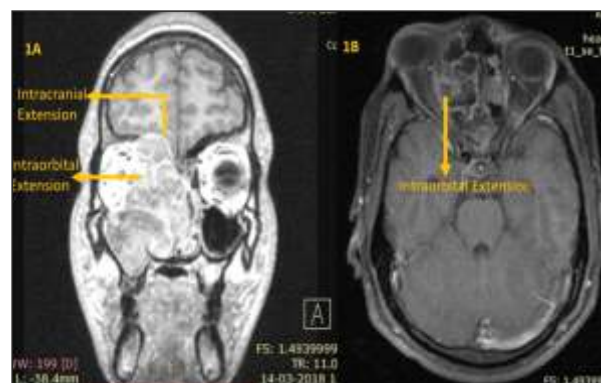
MRI Paranasal sinuses showing Sinonasal lesion with intraorbital and intracranial extension
